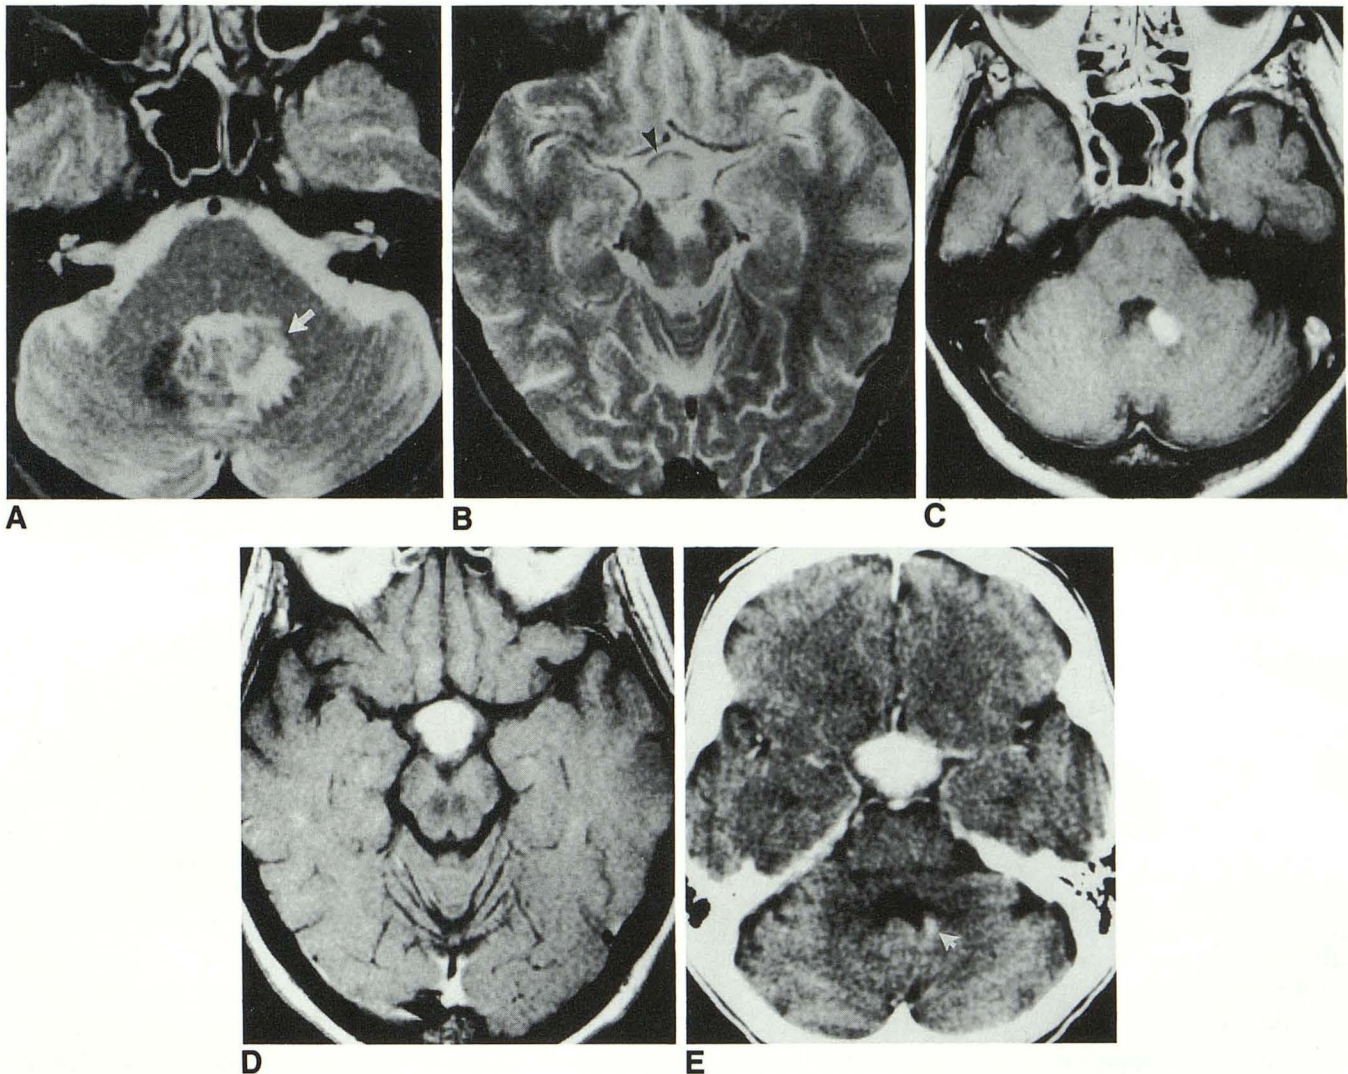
A, A T2-weighted (2757/80) MR image in patient 9 shows a lesion in the left cerebellar hemisphere with a Zone 1 area isointense to gray matter (*white arrow*) and a Zone 2 area abutting the fourth ventricle.
